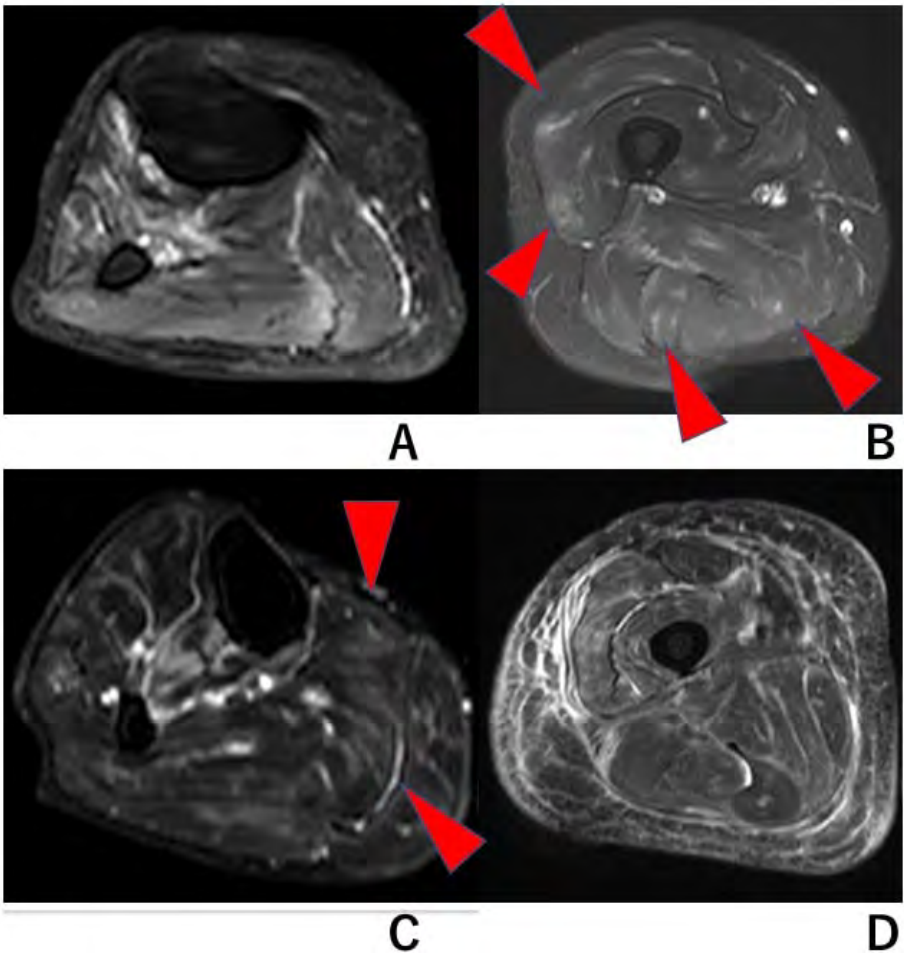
Muscle MRI of patterns of muscle signal alterations. MRIs show (A) “diffuse” (most area of the involved muscle show a high signal), (B) “perivascular” (a small area centered on blood vessels show a high signal), (C) “patchy” (geographic area of the involved muscle show a high signal), (D) “fascial lesion” (a high signal is seen in the fascia).
